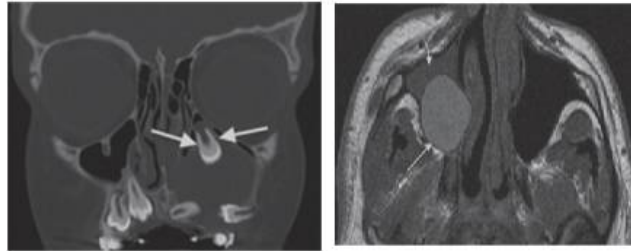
Dentigerous cyst. (A) Coronal bone CT shows a large cystic mass extending from around the crown and cemental- enamel junction (CEJ, arrows) of an unerupted tooth. The tooth is displaced superiorly, whereas the leading edge of the cyst has displaced surrounding unerupted teeth inferiorly. (B) Axial T1- weighted magnetic resonance (MR) image of a dentigerous cyst shows a sharply marginated hyperintense cystic mass (long arrow). Compare the hyperintensity of the cyst with the iso-intense (cf. muscle) signal of the associated mucosal thickening in the maxillary sinus (short arrow).
